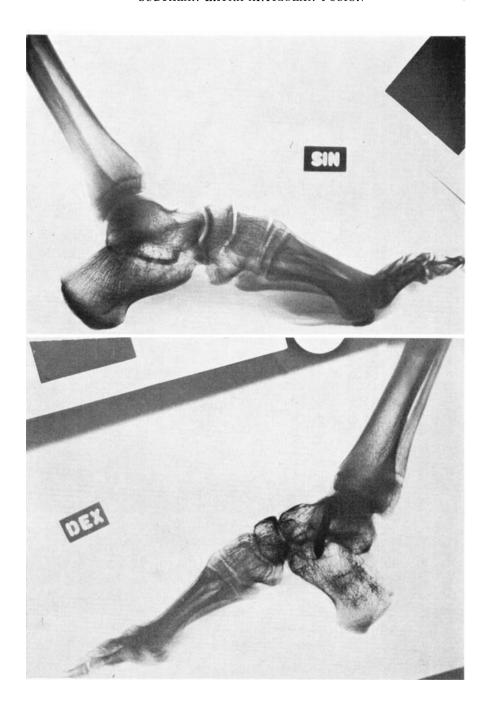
E. Roentgenograms twelve months postoperatively.
